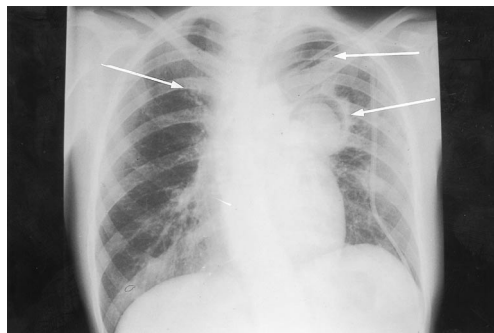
Plain chest radiograph with multiple primary aspergillomata in a bone marrow transplant patient.
